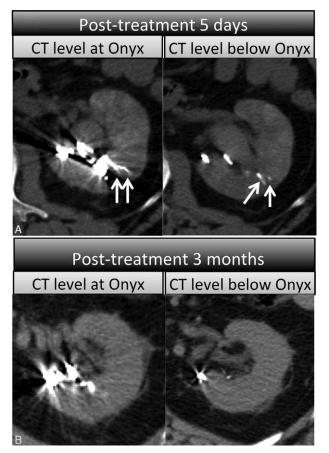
Multipanel imaging with comparison of the initial postembolization CT at 5 days after embolization and the subsequent CT at 3 months follow-up revealed the resolution of the striated tantalum powder. (A) Post-treatment follow-up (5 days): axial CT scan at the level of Onyx embolizer (left) and at a level below the Onyx embolization (right) revealed presence of hyperdense renal striation sign(arrows). (B) Post-treatment follow-up (3 months): axial CT scans at the same levels confirmed disappearance of the tantalum powder. CT, computed tomography.
